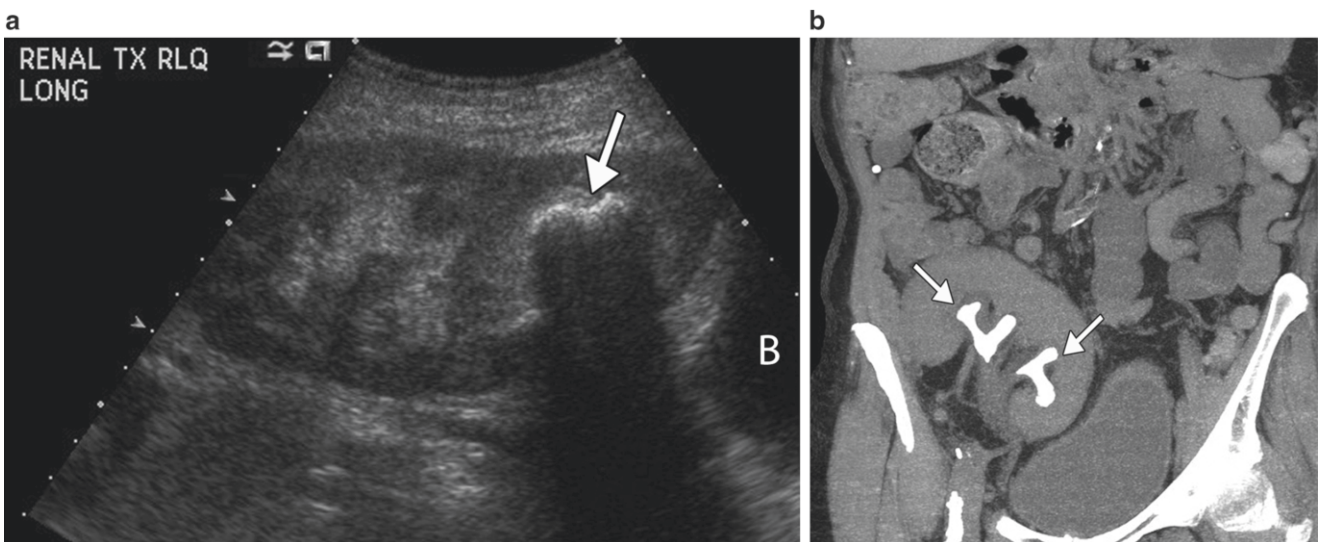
Calculus. (a) Longitudinal gray scale ultrasound showing a lower pole calculus (*arrow*). The calculus is echogenic and causes posterior acoustic shadowing. Bladder (*B*). (b) Coronal CT shows a branched calculus in the upper and lower calyces of a right lower quadrant transplant (*arrows*)
